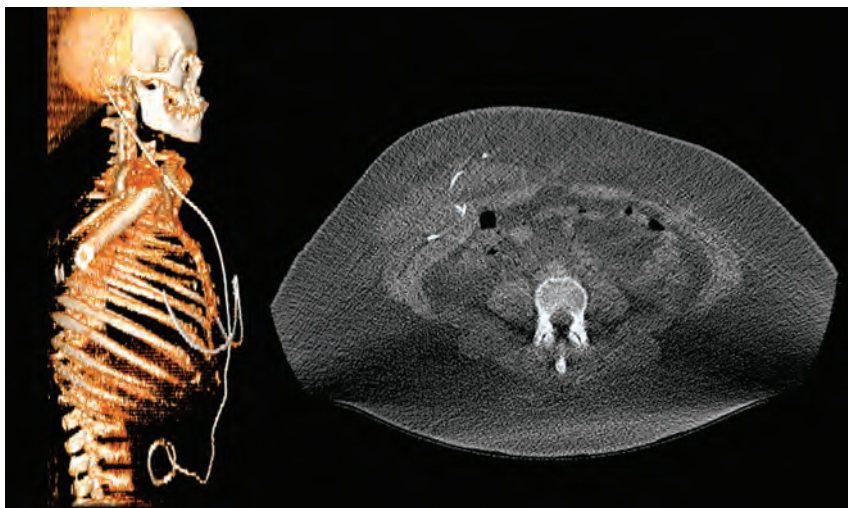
A 26-year-old woman with obesity (body mass index, 35.3 kg/m²) with idiopathic intracranial hypertension received a VP-shunt after the failure of conservative therapy. After the implantation of a VP-shunt, the correct intraperitoneal position of the distal catheter was verified by WB-ULD-CT. Two weeks later she was admitted due to progressive abdominal pain. WB-ULD-CT (lateral view on 3D reconstruction on the left and axial reconstruction on the right) shows an extraperitoneal shunt dislocation.
